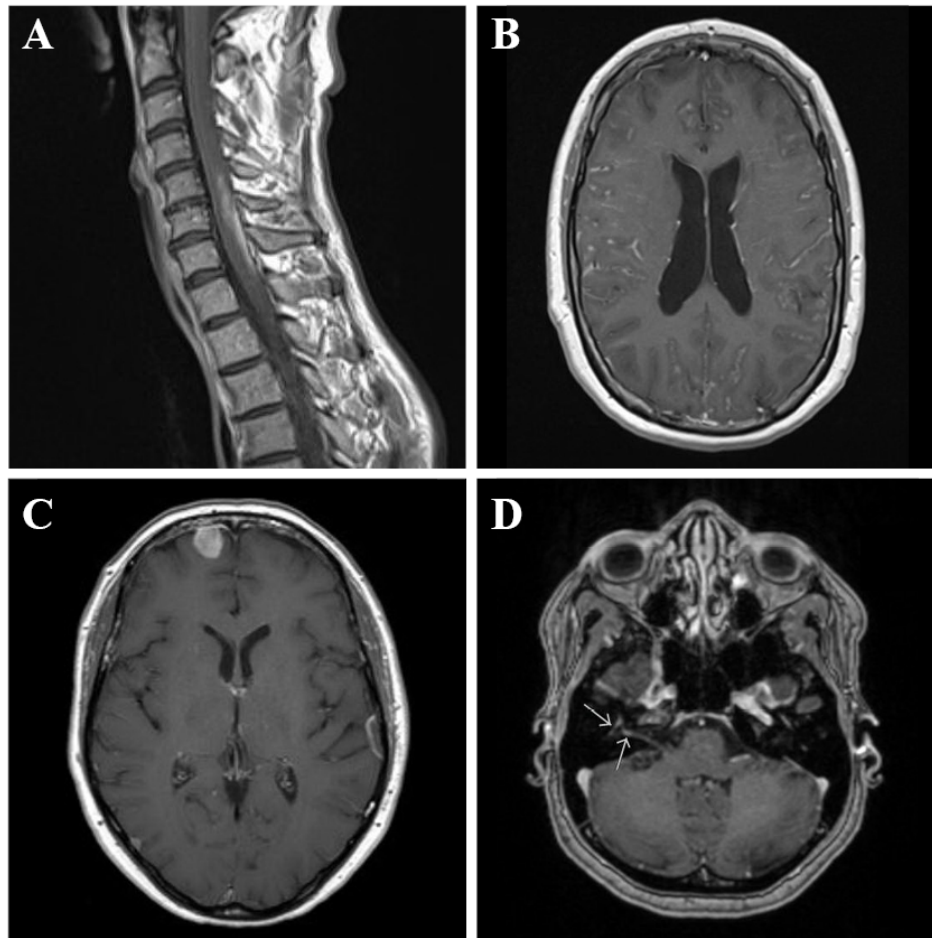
Abnormalities suggestive of neurosarcoidosis on neuroimaging. Abnormalities on magnetic resonance imaging (MRI) brain and spinal cord in patients with neurosarcoidosis consisting of gadolinium enhancement of a spinal cord lesion (A), leptomeningeal enhancement (B), gadolinium enhancement of dural lesions (C), and gadolinium enhancement of the right facial nerve (D).
